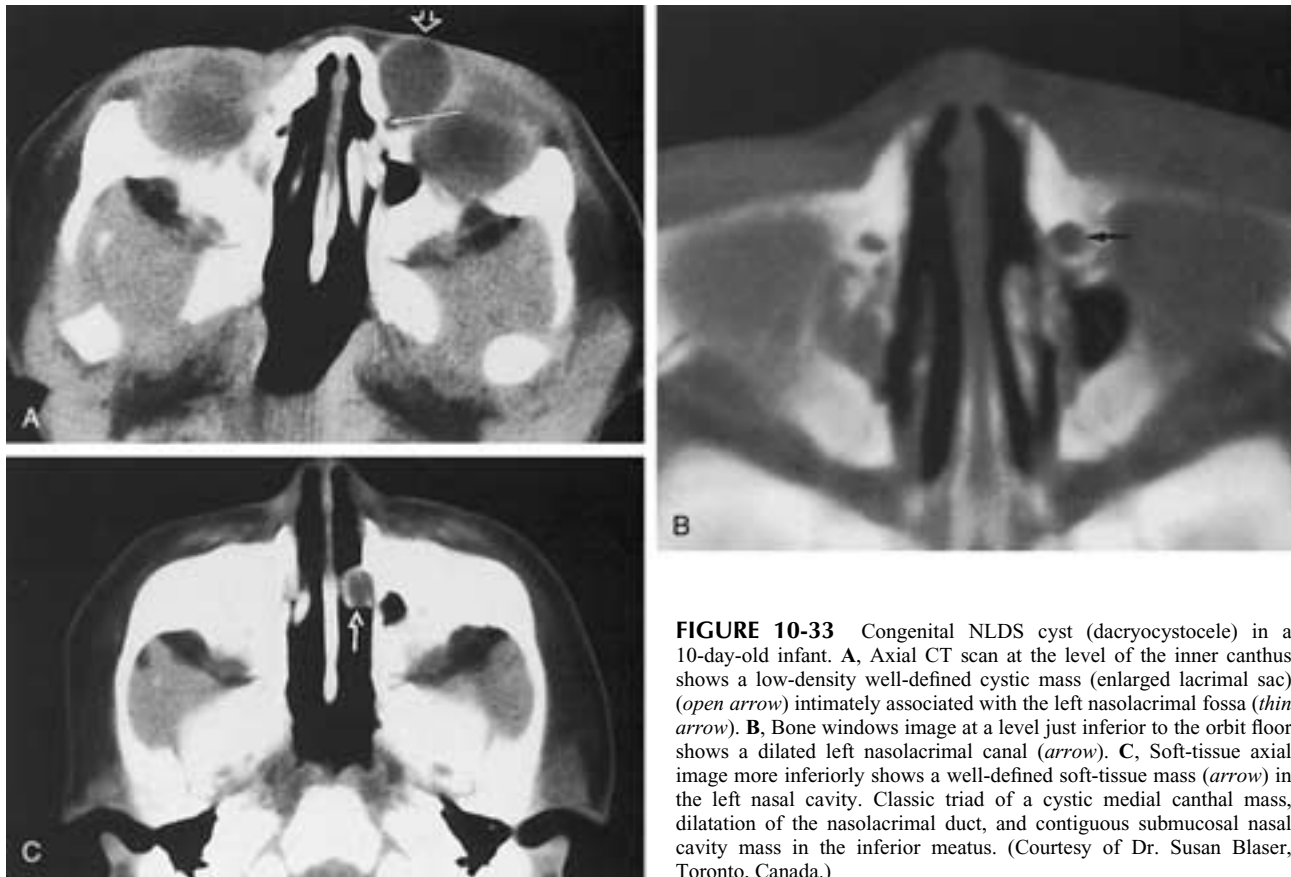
Congenital NLDS cyst (dacryocystocele) in a 10-day-old infant. A, Axial CT scan at the level of the inner canthus shows a low-density well-defined cystic mass (enlarged lacrimal sac) (*open arrow*) intimately associated with the left nasolacrimal fossa (*thin arrow*). B, Bone windows image at a level just inferior to the orbit floor shows a dilated left nasolacrimal canal (*arrow*). C, Soft-tissue axial image more inferiorly shows a well-defined soft-tissue mass (*arrow*) in the left nasal cavity. Classic triad of a cystic medial canthal mass, dilatation of the nasolacrimal duct, and contiguous submucosal nasal cavity mass in the inferior meatus. (Courtesy of Dr. Susan Blaser, Toronto, Canada.)
